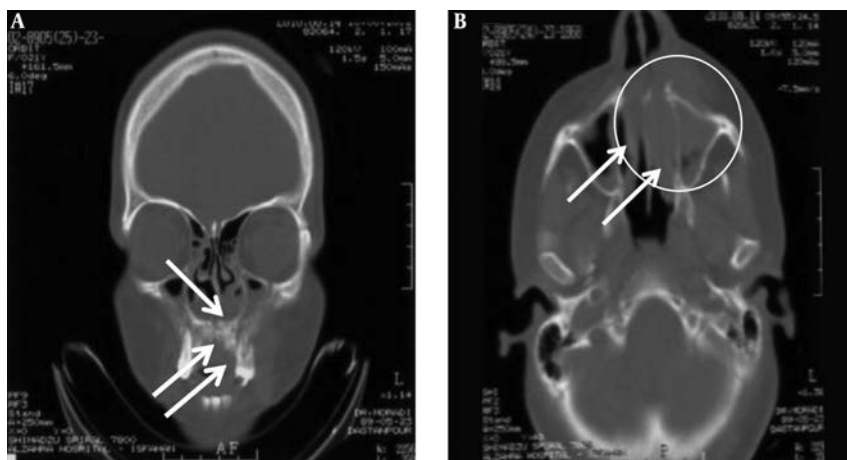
CT Scan Views of a Soft Tissue Mass in the Anterior of the Maxilla with Expansion Into the Left Nasal Cavity and Maxillary Sinus in the Coronal, A and Axial, B View
